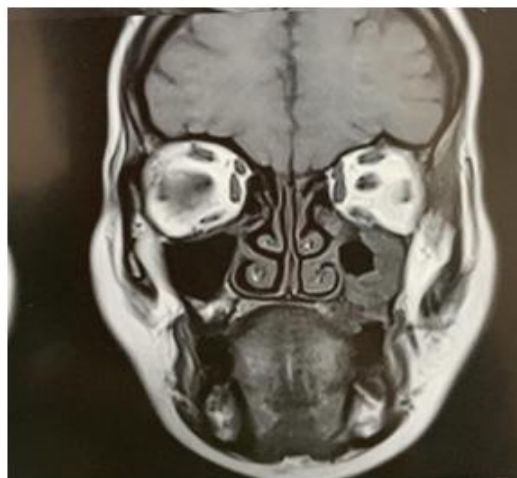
MRI of patient with left maxillary sinus involvement extending to infraorbital rim
